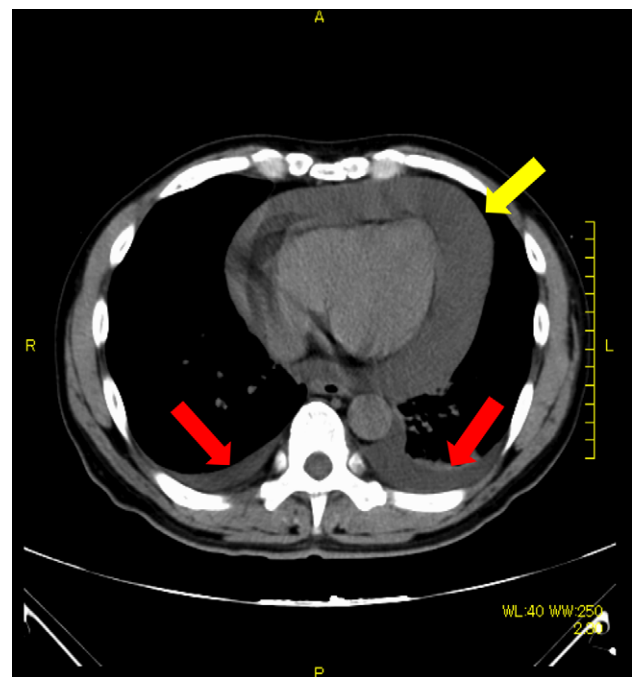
Plain CT scan showing the cardiac tamponade caused by pericardial effusion (yellow arrow) and pleural effusion (red arrows). The pericardial effusion displaced the cardiac muscle.
